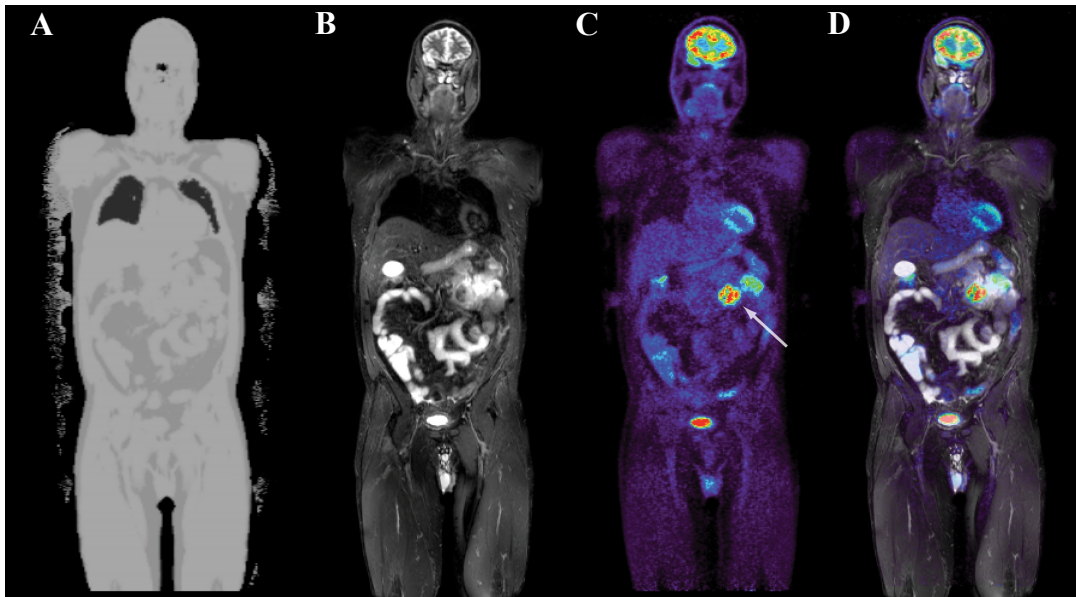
PET/MRI of a melanoma patient. (A) MRI derived attenuation map and (B) T_2 -weighted anatomy image, (C) ^{18}F -FDG PET scan, (D) and an overlay of both the previous images. The arrow in panel C indicates an enteric melanoma metastasis. Figure adapted from Disselhorst et al. [65].
